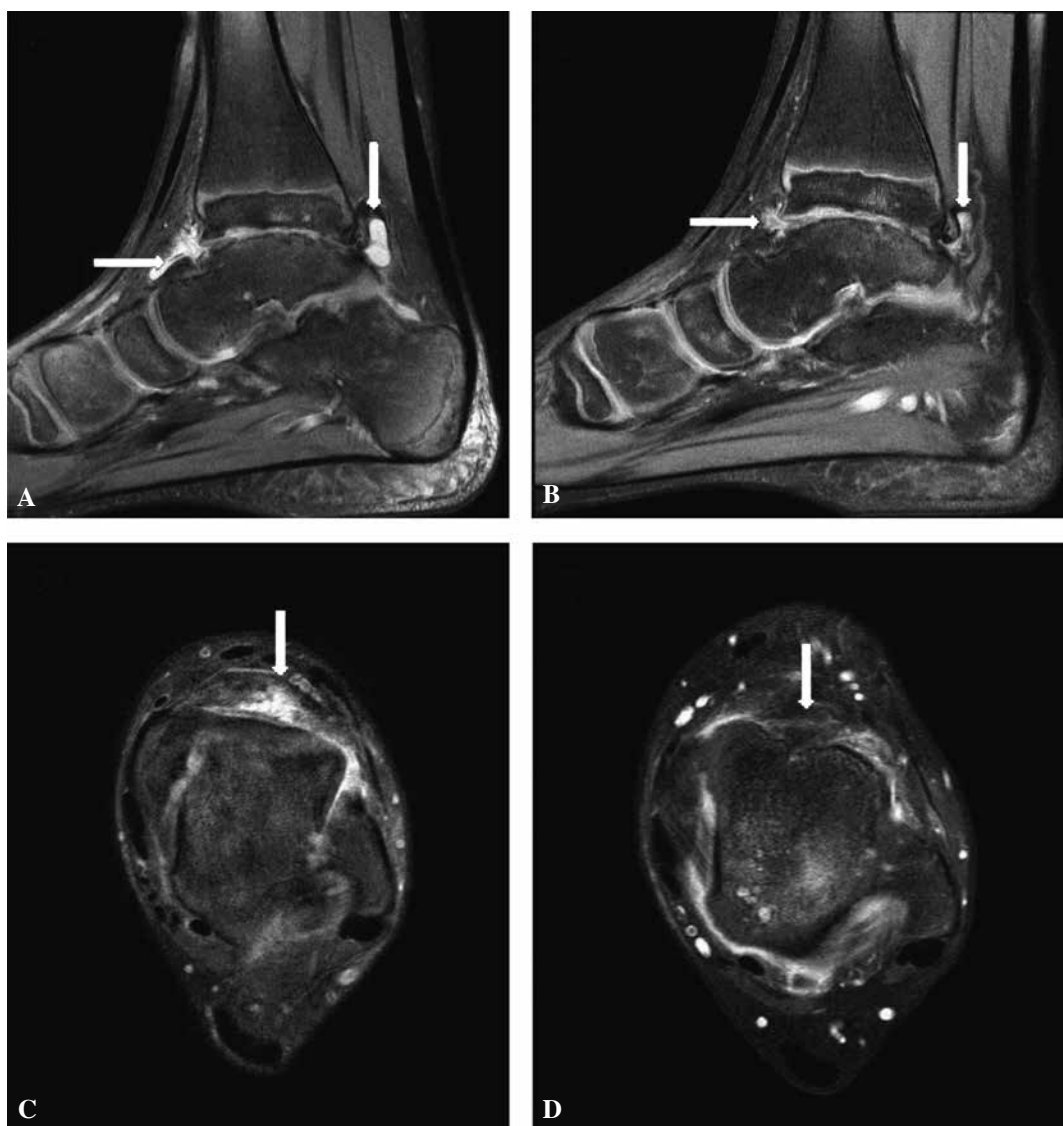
MRI of the left ankle joint.
